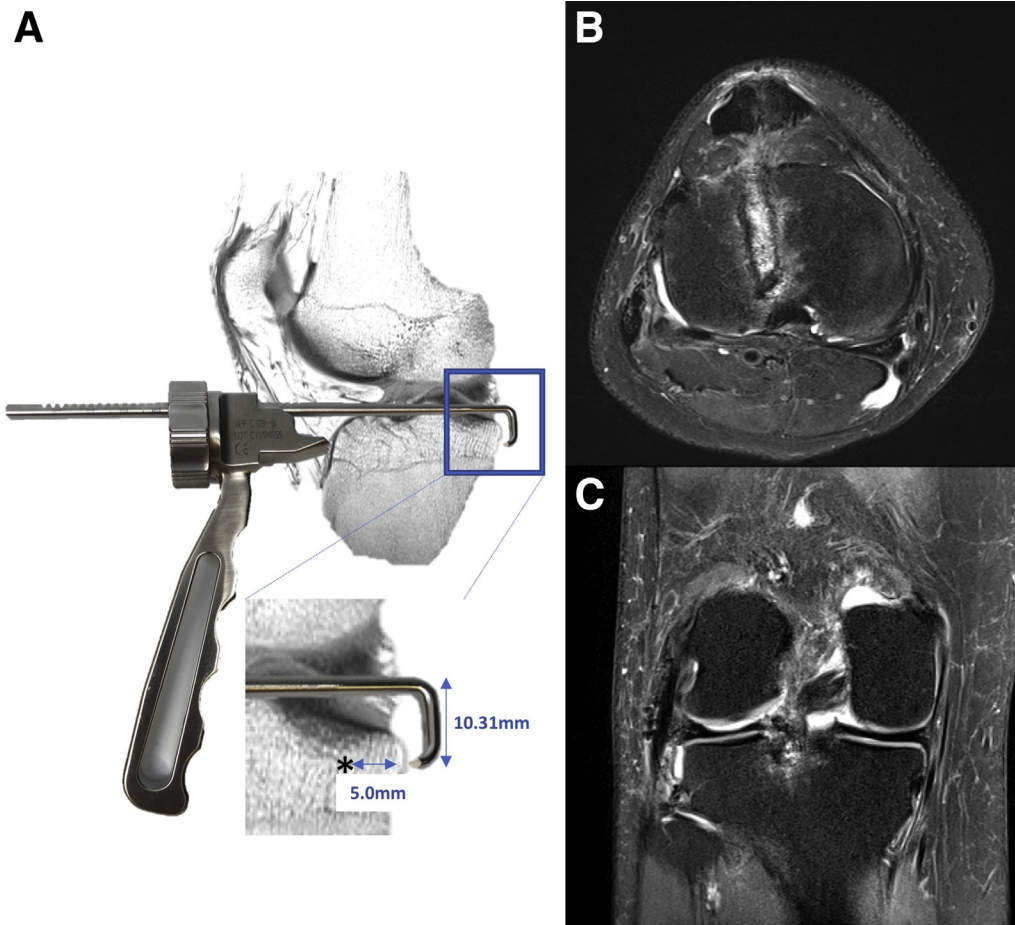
The tibial drill guide (A) comprises a tibial hook and a toothed handle with a worm gear. The guide is placed through a patellar tendon split (B) allowing alignment of the trough directly over the anterior and posterior meniscal roots at an angle parallel to the plateau slope. (A) Portions of the spine, seen here as they overlap the guide, must be removed along this axis to allow appropriate positioning. The worm gear secures guide teeth to the anterior plateau and creates a stable platform for trough preparation. Using this guide, the tip of the tibial drill, guide pin, and reamer will allow for maintenance of a 5-mm back wall with a depth 10.31 mm below the subchondral plate. Axial and coronal magnetic resonance imaging images (B and C) performed 2 weeks postoperatively show the anatomic position of the anterior and posterior roots of an allograft implanted with this technique. Note the absence of any significant extrusion on the coronal view (C).
